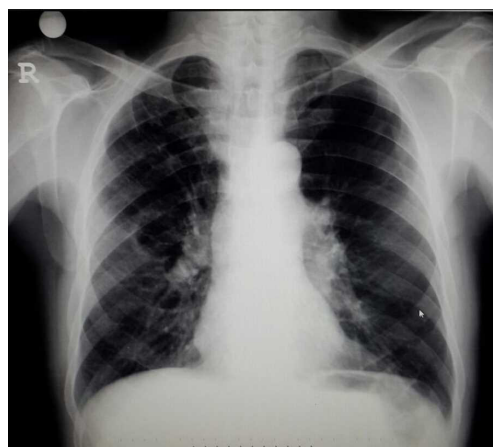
Chest x-ray showing a non-homogenous opacity in the right middle zone, and the left hilar enlargement
